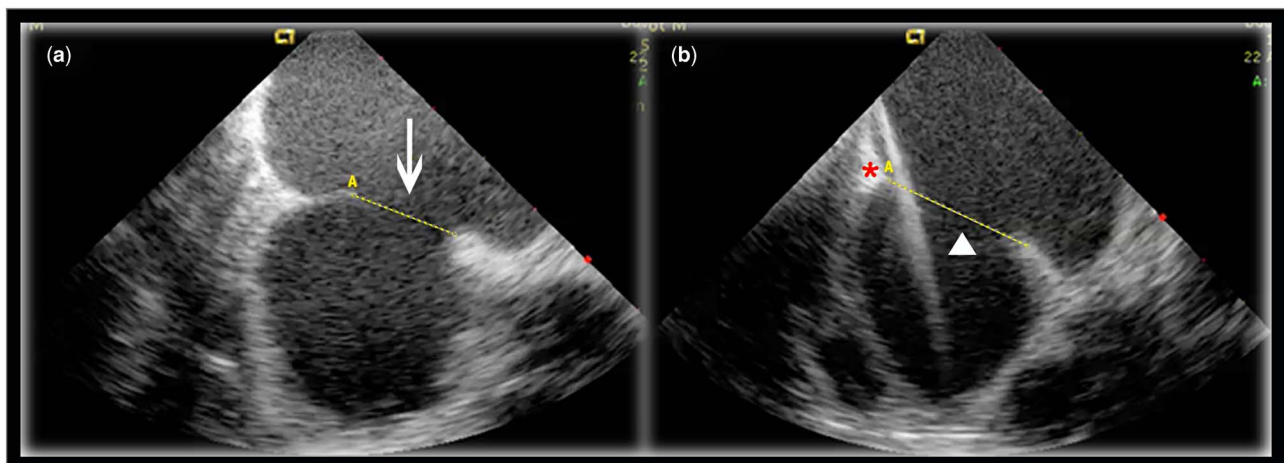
Short-axis intracardiac echocardiogram. (a) Measured basal diameter (arrow). (b) Catheter expanded diameter (tip of the arrow); the movement of the posteroinferior border can be observed (asterisk).
